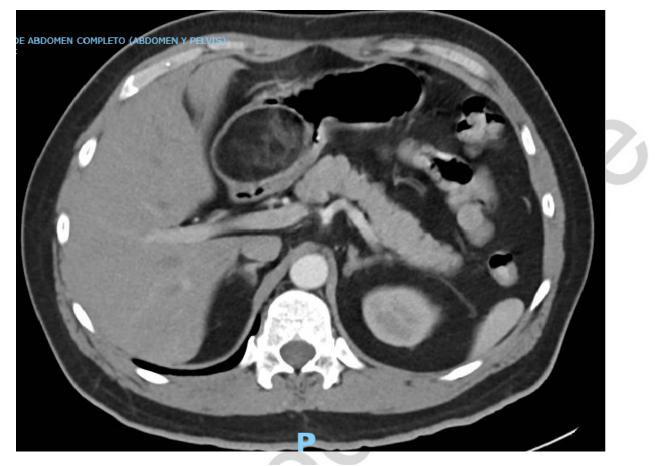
Abdominal CT: a homogeneous, well-delimited fat-density mass measuring 5.9 x 4.3 cm in the gastric antrum.
